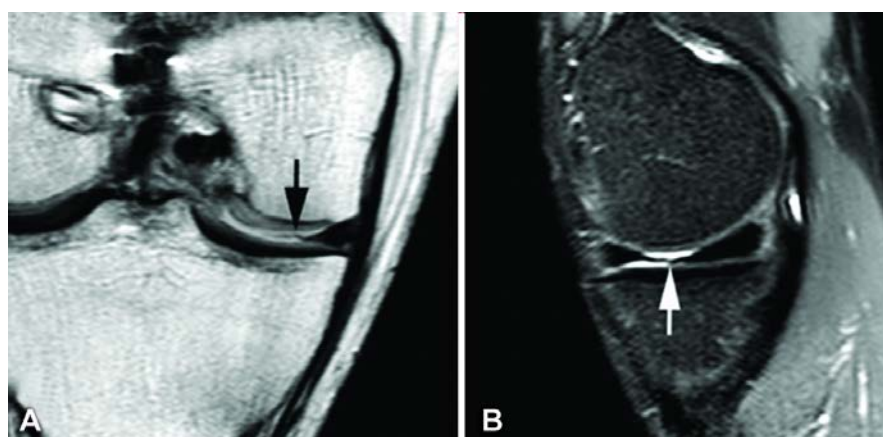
MRI scans of the right knee in a 32-year-old patient V.: A – deformed course of the inner meniscal edge on coronal plane; B – deformed meniscal 'butterfly' shape with no signs of distortion of meniscal founce on sagittal plane
